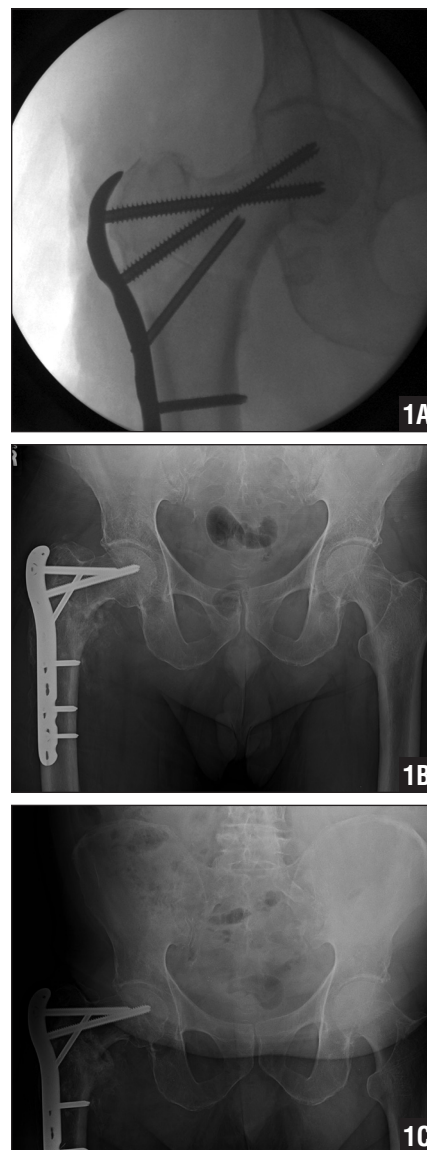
Patient 6. Intraoperative fluoroscopy (A) and postoperative anteroposterior radiographs at 10 weeks (B) and 7 months (C) demonstrating stable varus collapse.
